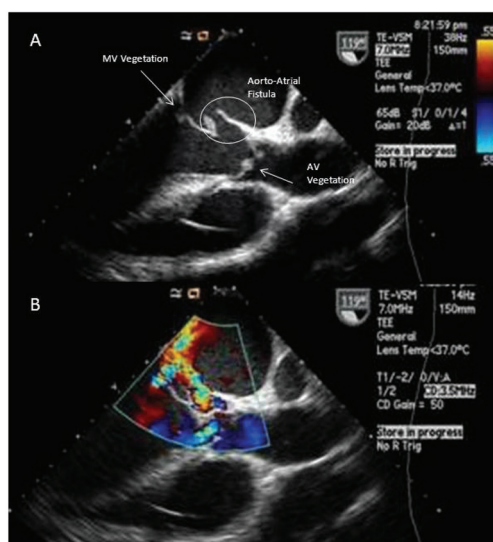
(A) TEE demonstrating Aorto-Left Atrial fistula, vegetation on Mitral and Aortic Valves (B) Color doppler
